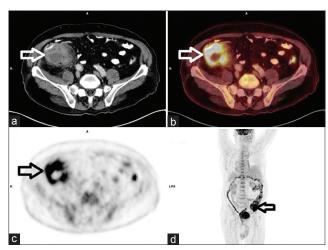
(a) Computed tomography (CT) revealed the cecum to be prominently enlarged. The cecum enlarged to 60 mm × 70 mm and the cecum walls exhibited hypertrophy (arrow). (b) The results of flourodeoxyglucose-positron emission tomography (FDG-PET) coincided with the mass portion observed in CT and abnormal accumulation of FDG was observed. The maximum standardized uptake value was elevated at 22 (arrow). (c and d) The results of FDG-PET coincided with a tumor-like shadow observed in CT and abnormal accumulation of FDG was observed (arrows) (c: Axial image; d: MiP-maximum intensity projection image)
